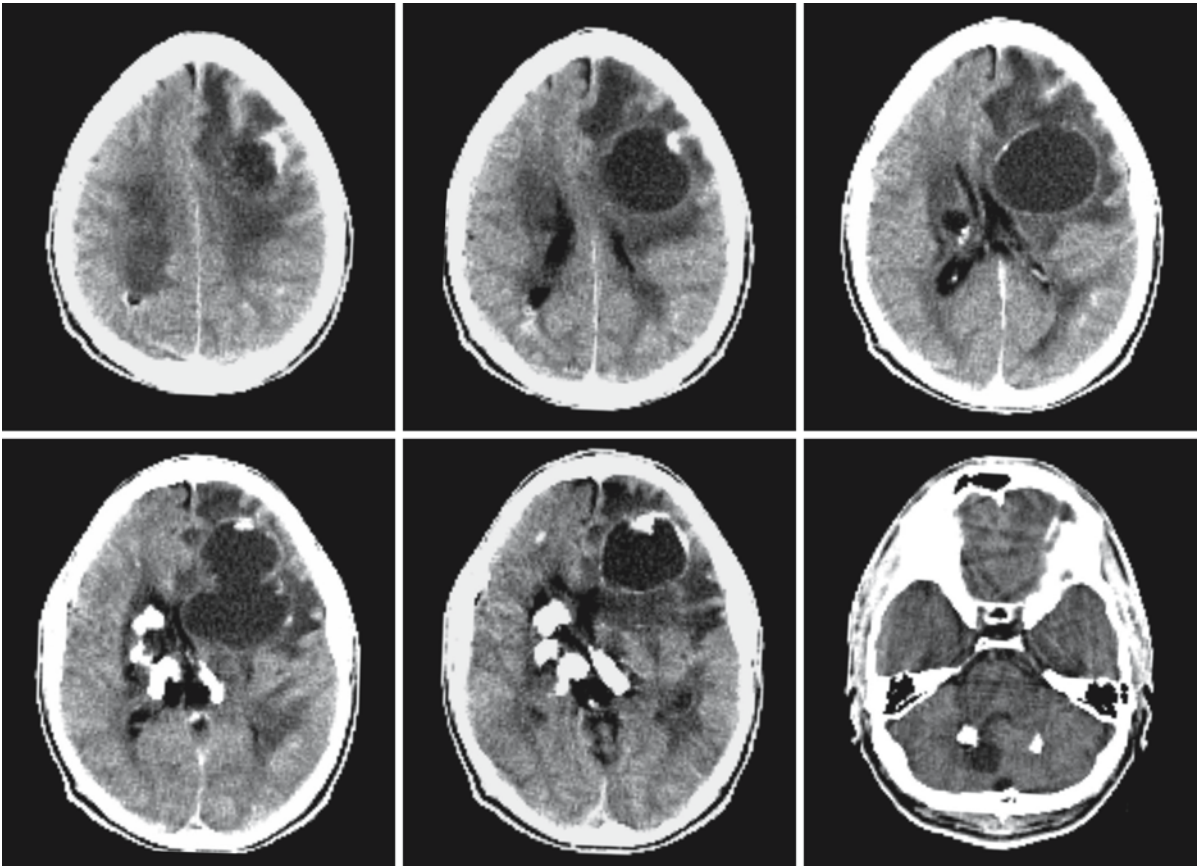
CT scan at the age of 22 reveals the increase in calcium as compared to the first CT (Fig. 67.3)
